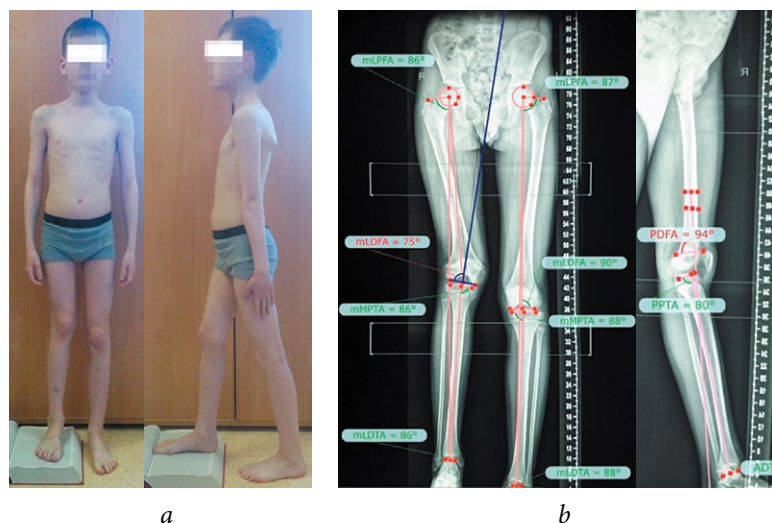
Patient G., 12 years old, with the consequences of hematogenous osteomyelitis of the right hip, before treatment: *a* — appearance; *b* — panoramic radiographs of the lower extremities, mechanical axes of the proximal and distal sections are drawn
